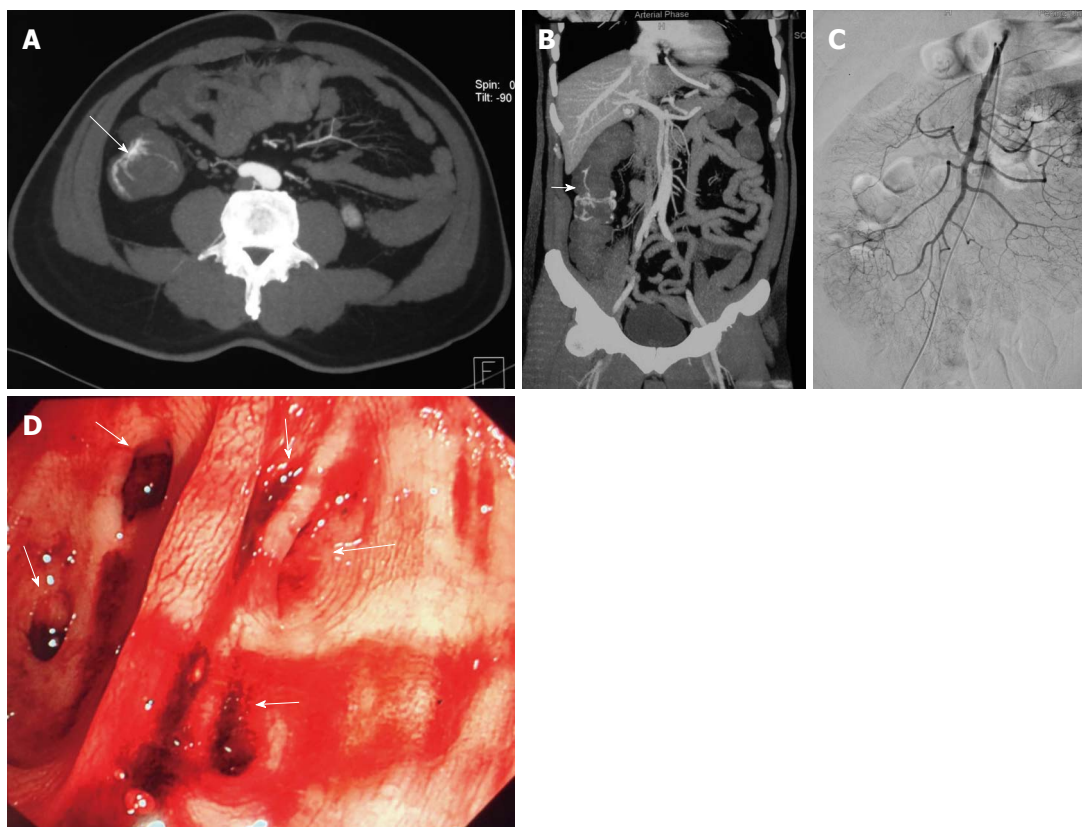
Imaging of case 2. A: Abdominal computed tomography (CT) revealed contrast extravasation in the ascending colon (arrow); B: CT angiography revealed bleeding from the intramural branches of the marginal artery supplying the ascending colon (arrow); C: Angiography failed to reveal the precise location of the bleeding; D: Emergent colonoscopy revealed multiple diverticula in the middle part of the ascending colon without definite bleeding vessels identified (arrow).
